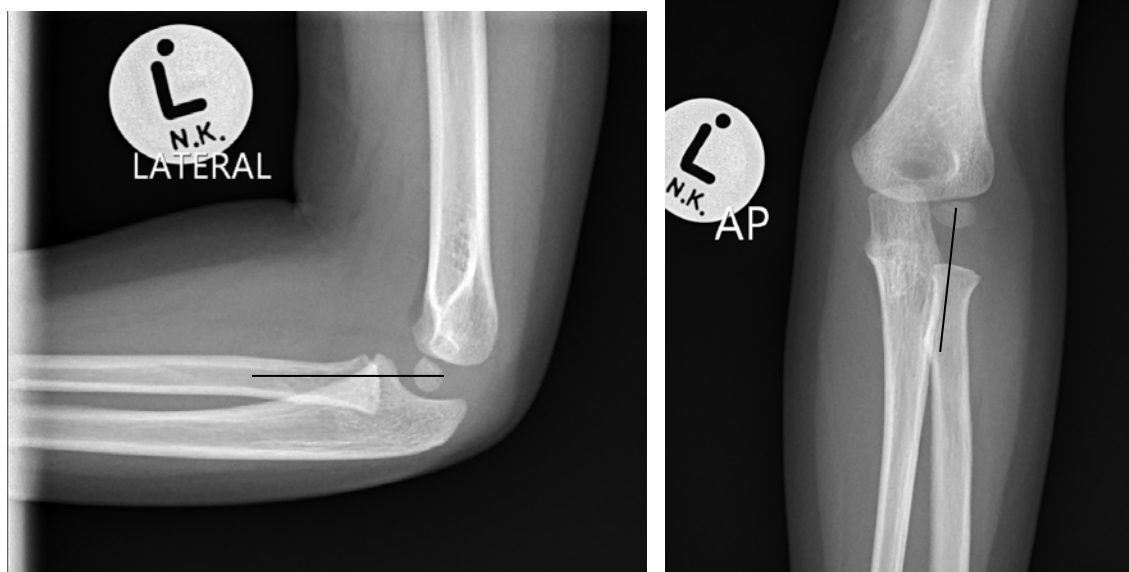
AP and lateral radiograph with a normal radiocapitellar line
